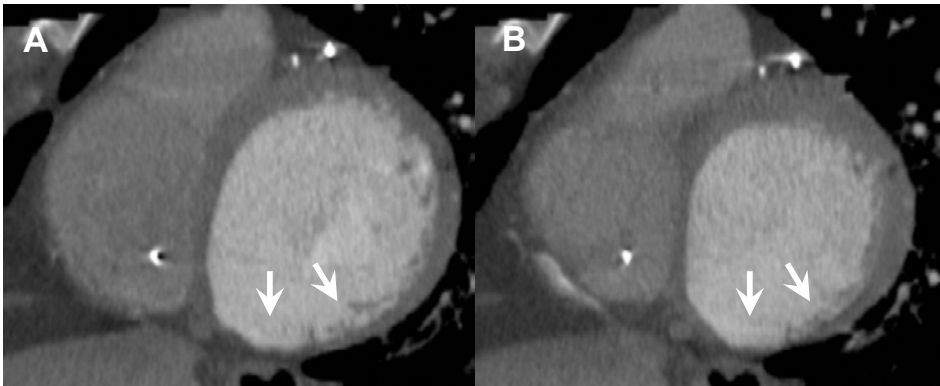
Evaluation of LV function with CTA. Short-axis view of end-diastolic phase (A) and end-systolic phase (B). Akinesia and thinning of myocardium can be observed in the inferolateral wall, due to previous myocardial infarction. Assessment of global LV function revealed a severely reduced LVEF of 18%.
